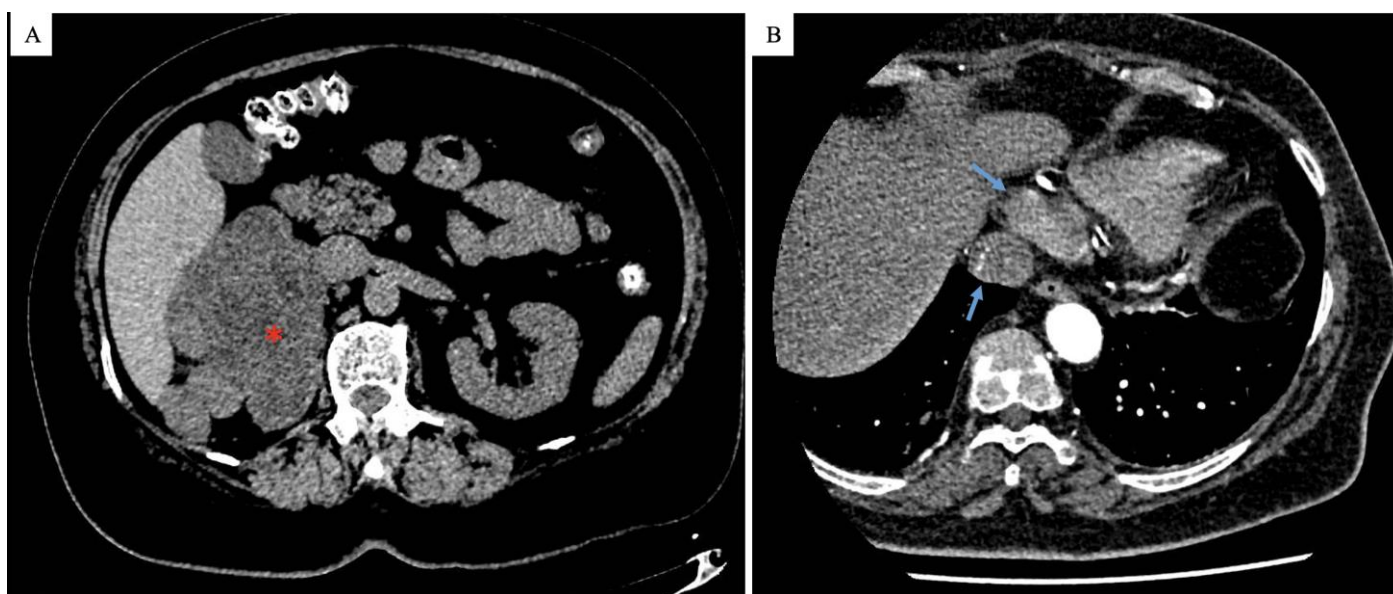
(A) Abdominal CT scan showing a voluminous neoplastic mass involving the right side of the abdomen (10×7.5 cm), presumably arising from the right adrenal gland, with liver involvement (*); (B) a cardiac computed tomography angiography (CTA) showing a bilobed, inhomogeneously hypodense mass in the RA, in continuity with the IVC (arrows).
